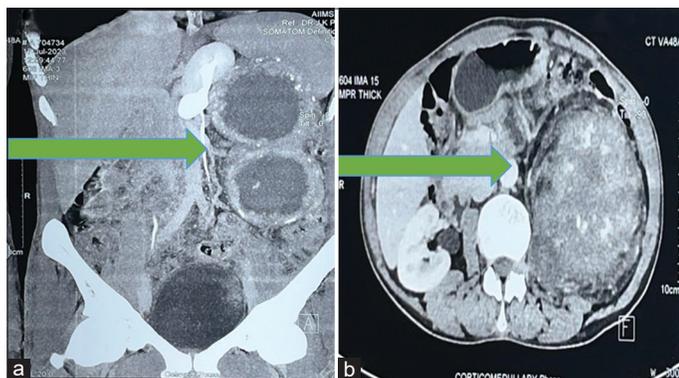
On contrast-enhanced computed tomography (abdomen) lesion size was 18.8 × 10.8 × 18.8 cm with multiple foci of internal calcification and necrosis. Anteriorly it was displacing the left kidney and ureter anteromedially, pancreas body, and tail superoanteriorly, with anterior displacement of splenic flexure. Medially, displacing the abdominal aorta and its branches to the right side. Laterally, it maintained a fat plane with a spleen and abdominal wall. Lesion extension was from D11 to L 5 vertebra
